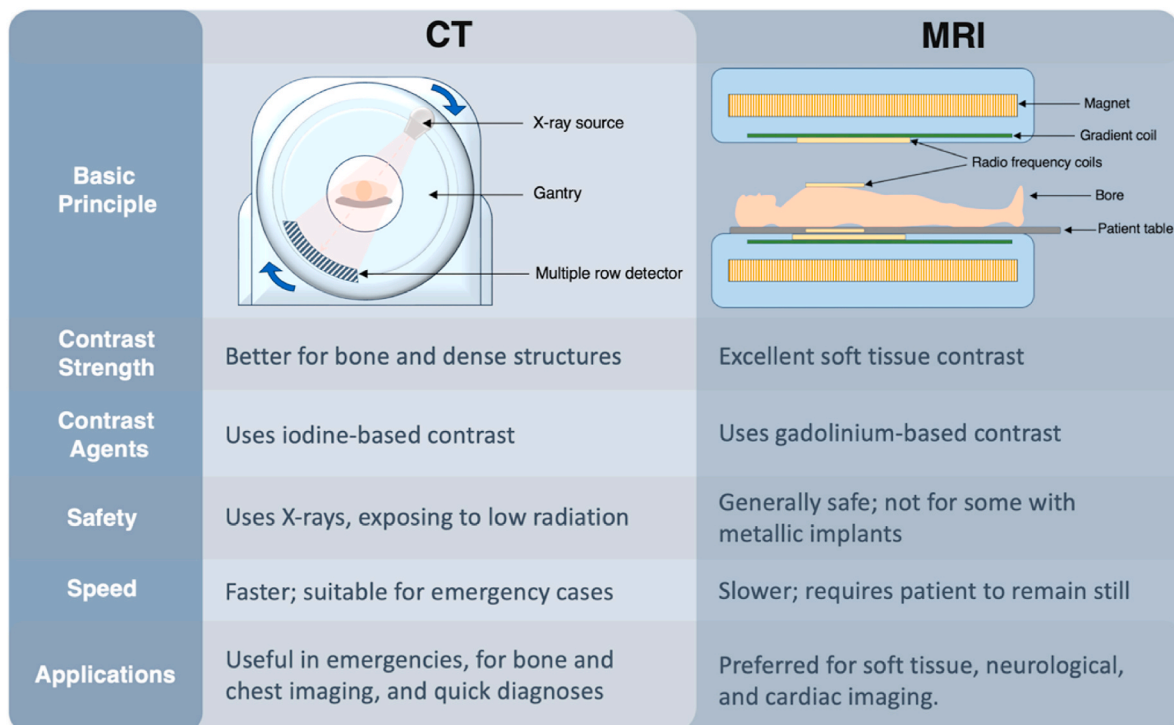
Comparison between CT scan and MRI.
